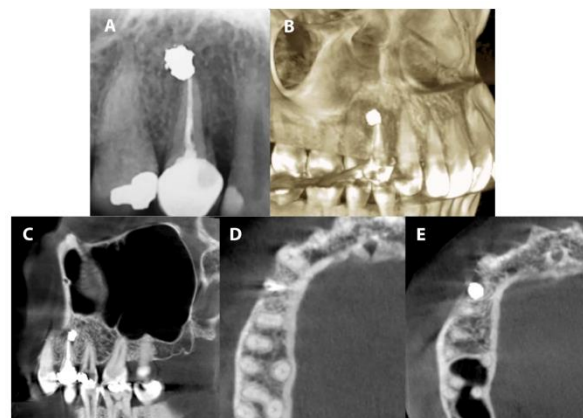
Periapical and cone beam computed tomography (CBCT) images: (A) Periapical radiograph: excess rate of amalgam, (B) 3 dimensional view of CBCT, (C) sagittal view of CBCT (D, E) axial views of CBCT
